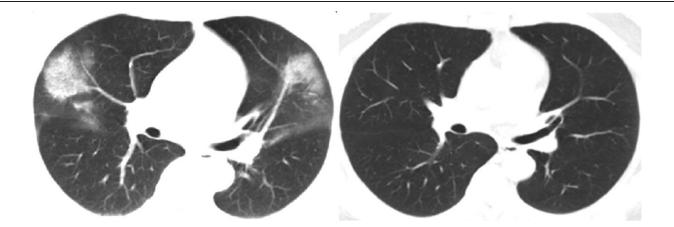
Chest CT images of patient 9 with COVID-19 caused by one-time community exposure. (A) Chest CT images showed the bilateral GGOs on day 12 after symptom onset. (B) Chest CT images showed the near-complete resolution of bilateral GGOs at 1-mo follow-up after discharge.
